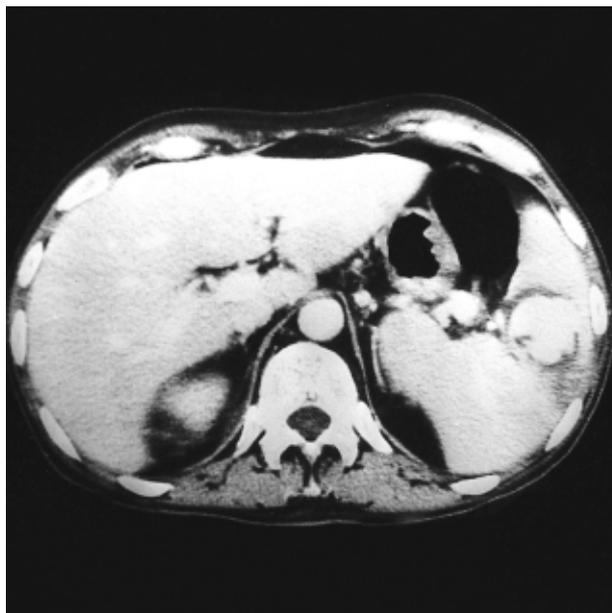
Abdominal CT reveals splenomegaly, and a well defined highly enhanced lesion with non-enhanced peripheral portion about 4 × 3 cm in diameter in the perihilus of the spleen, which is most likely the intrasplenic pseudoaneurysm with peripheral thrombi formation.
